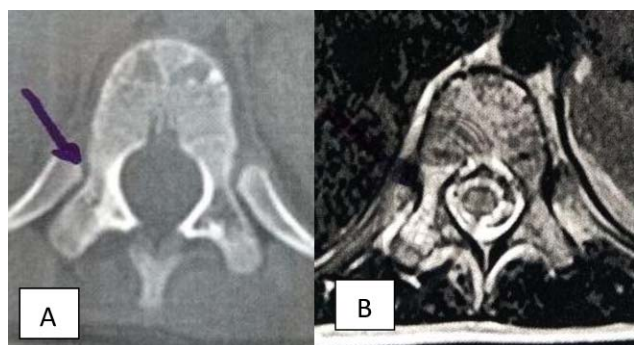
(A) Axial computed tomography of the spine. The image shows absence of the right T11 pedicle, its space being replaced by cell attenuation coefficient material. (B) Axial T2-weighted magnetic resonance image. The image shows the right T11 pedicle with local hypersignal, indicating spondylolysis without signs of listesis.
